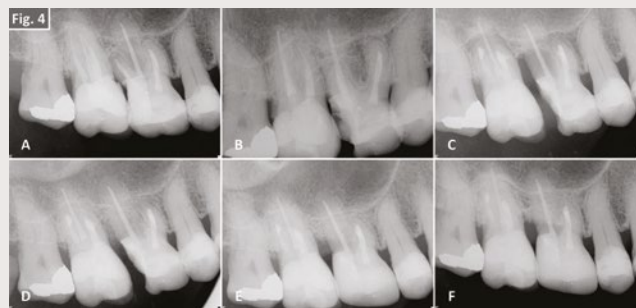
Periapical radiograph showing a radiolucent lesion surrounding the distobuccal root and furcation region of tooth 16 (A). Periapical radiograph after selective palatal root canal retreatment of tooth 16 (B). Intra-operative radiograph following the distobuccal root resection of tooth 16, along with apicoectomy, retro-preparation and retro-filling of the remaining buccal canals of teeth 17 and 16 (C). Immediate postoperative radiograph after guided tissue regeneration (D). Radiograph four months (E) and 27 months (F), highlighting sustained healing and bone regeneration.
